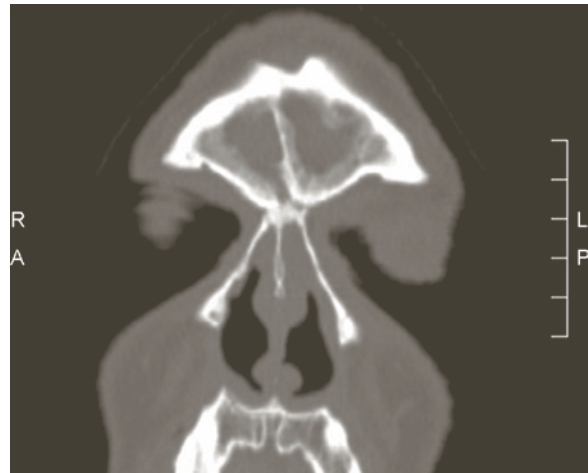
CT scan showing neo-osteogenesis/osteitis
